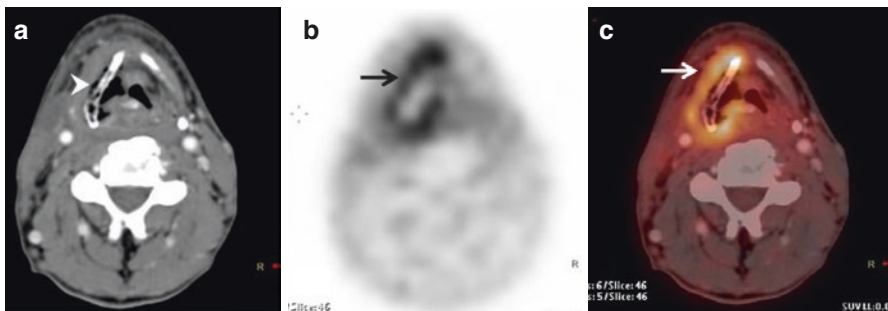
Evaluation after chemo-radiotherapy. Axial CT, PET and fused PET/CT show malignancy of the right pyriform sinus (*arrowhead* in a, *arrows* in b and c). Scan done after 8 weeks of chemoradiation treatment shows focal uptake (*arrows* in e and f) in an enhancing lesion in the pyriform sinus (*arrowhead* in d) suggesting residual disease. PET/CT done after 6 weeks of radiation in another patient shows uptake in the pyriform sinus which is more diffuse in nature (*arrows* in h and i) due to post radiation inflammation and not residual disease
